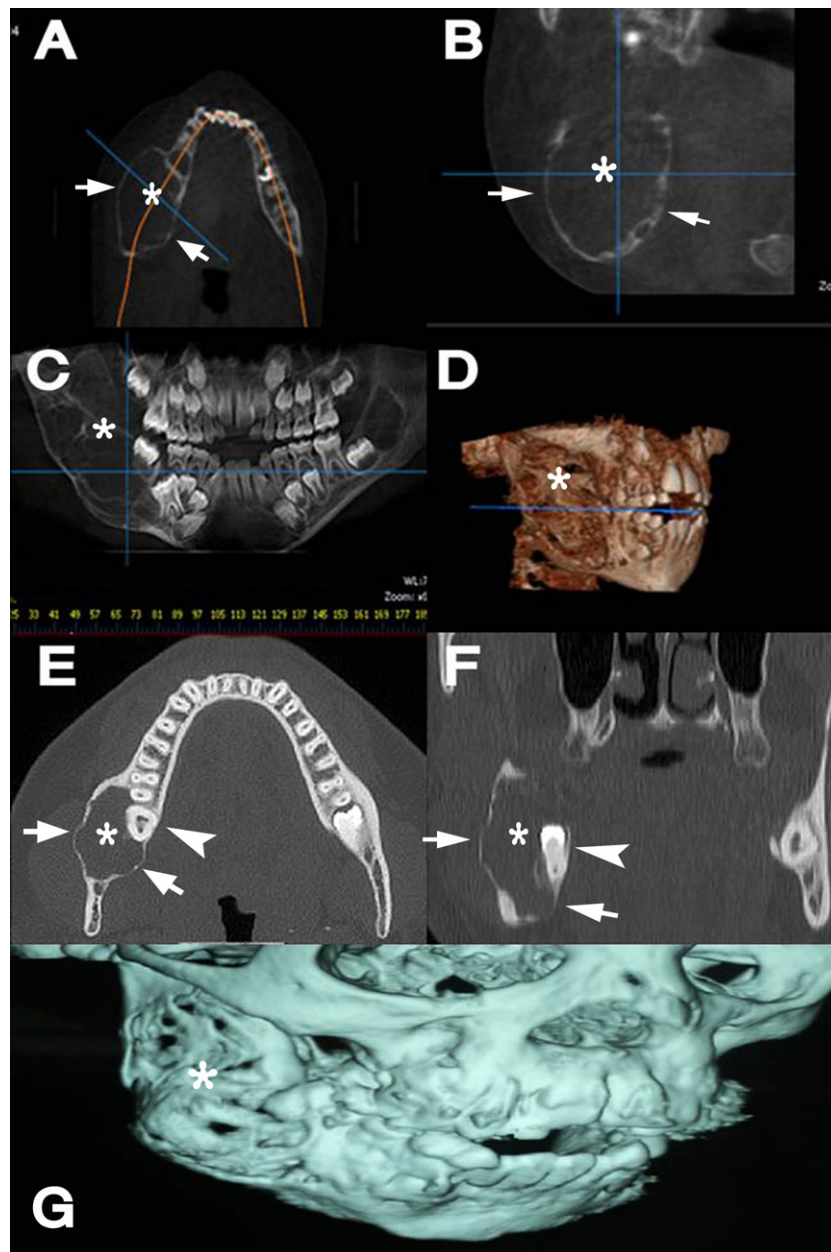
Ameloblastoma. *CBCT*: A–D (axial, coronal, panoramic reformatted and 3D images, respectively). *MDCT*: E–G (axial, coronal MIP and 3D volume-rendering images, respectively). Both modalities were identical showing well-circumscribed radiolucent lesions involving the right mandibular ramus (asterisk) with tooth displacement (arrow heads). Both buccal and lingual plates were expanded, scalloped and thinned with no evident erosion (short arrows).
